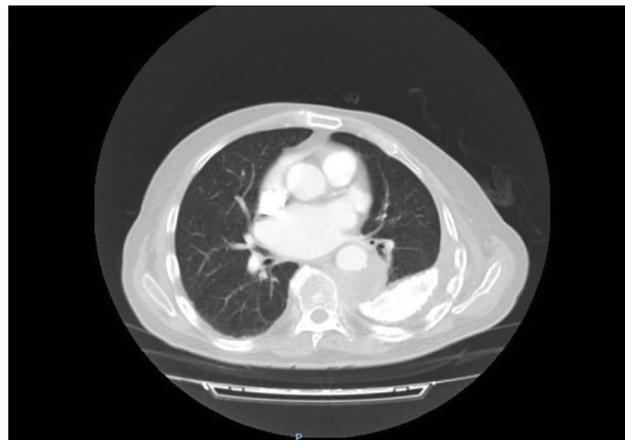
Chest CT slice showing the lesion. An adjacent area of para-aortic pulmonary consolidation and left posterior pleural calcification can be observed.
